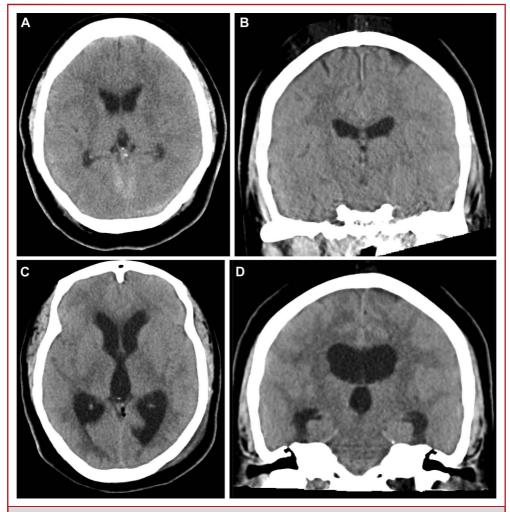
Initial postoperative computed tomography images demonstrating normal ventricular caliber in the A, axial and B, coronal planes. Developing hydrocephalus is observed in the C, axial and D, coronal planes.
